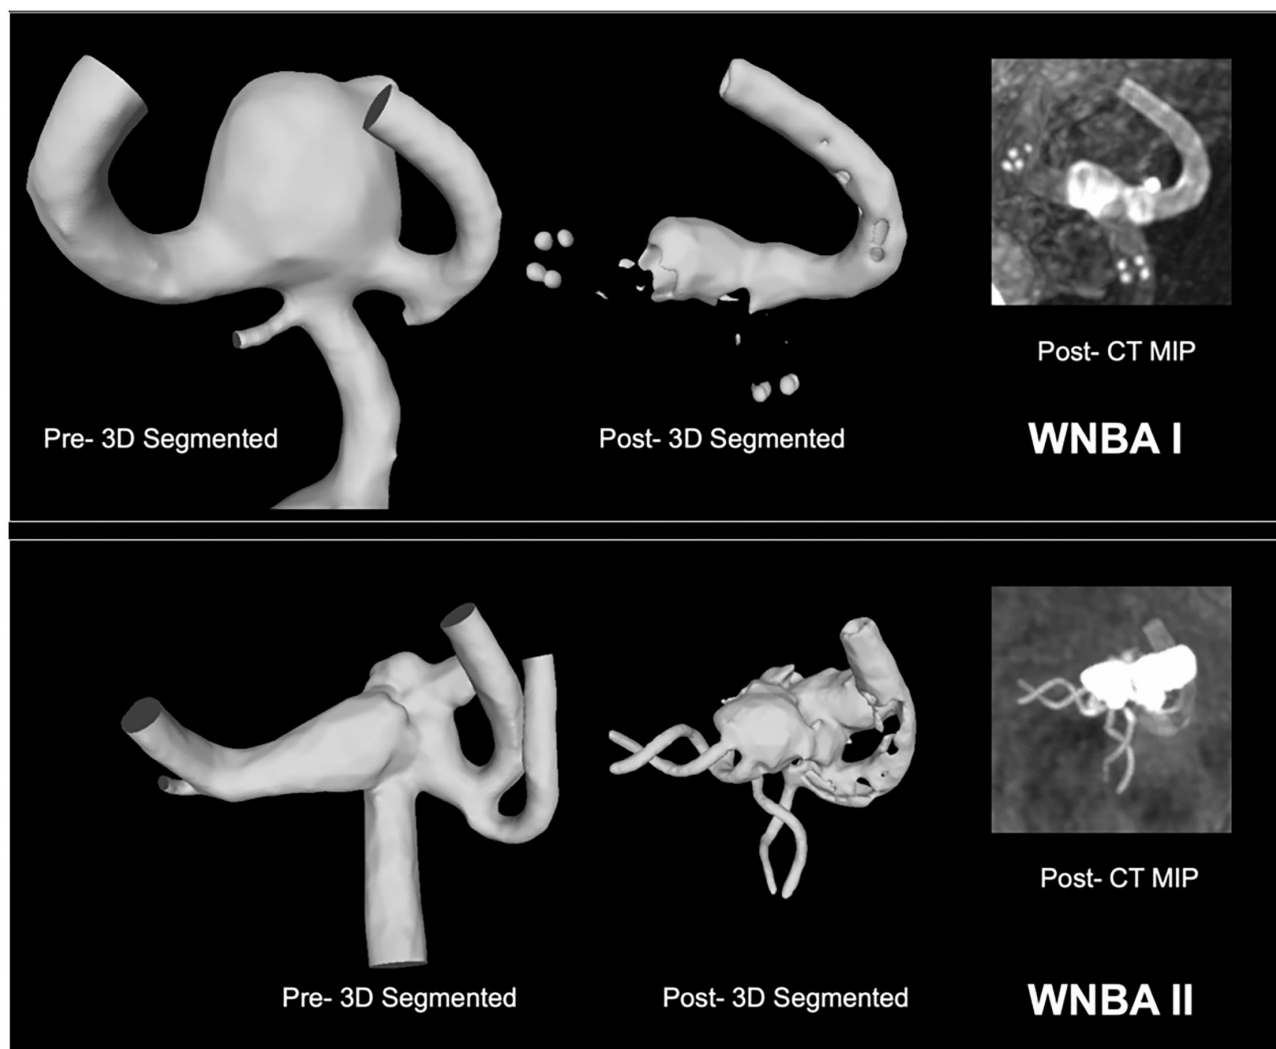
WNBA geometries I and II reconstructed from CT angiography pre-intervention with Flow-T for virtual stenting (left) and post-intervention for reference (right). Flow diverters placed in the secondary daughter vessel (right-hand in both orientations) are fully visible while the stent placed in the primary daughter vessel is indicated with end (LVIS EVO) or helical (Baby Leo) markers.
